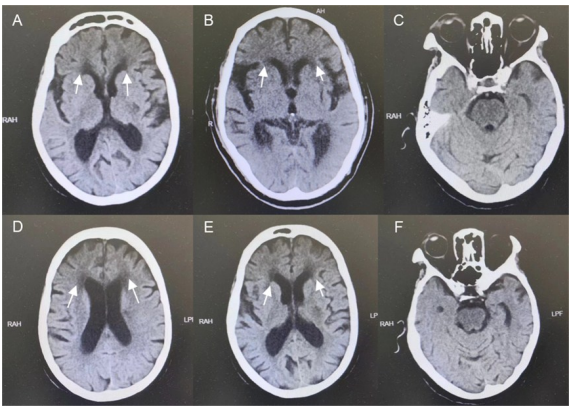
CT image of the brain in typical CSVD patients. A, B, and C are from a 64-year-old patient with CSVD, and E, F, and G are from another 72-year-old patient with CSVD. The arrows demonstrate the lesion areas in the images. CSVD: cerebral small vessel disease.
